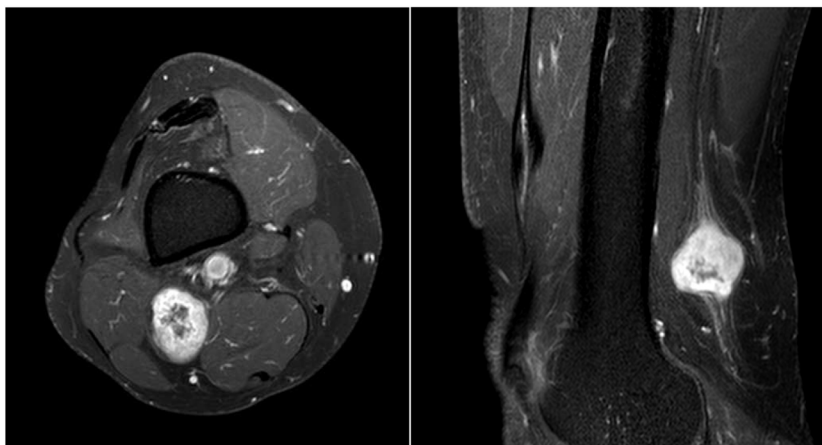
Fat-suppressed T1-weighted axial and sagittal MRI sequences with contrast administration, showing marked peripheral contrast uptake with heterogeneous central areas not displaying contrast uptake.
